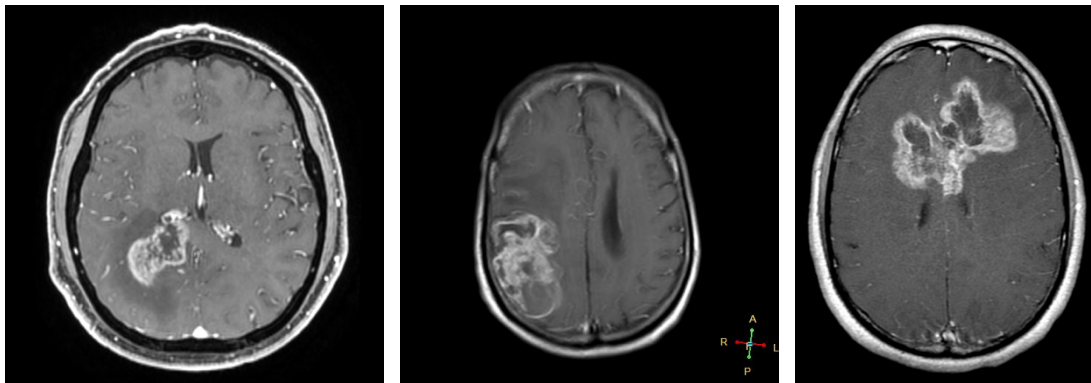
MRI scans of glioblastomas are shown. The left (31) and middle (32) scan show ring-shaped irregular contrast enhancement on T1-weighted scans, central hypointensity as a sign of necrosis and irregular tumor margins; the right (33) scan shows a butterfly glioblastoma.
